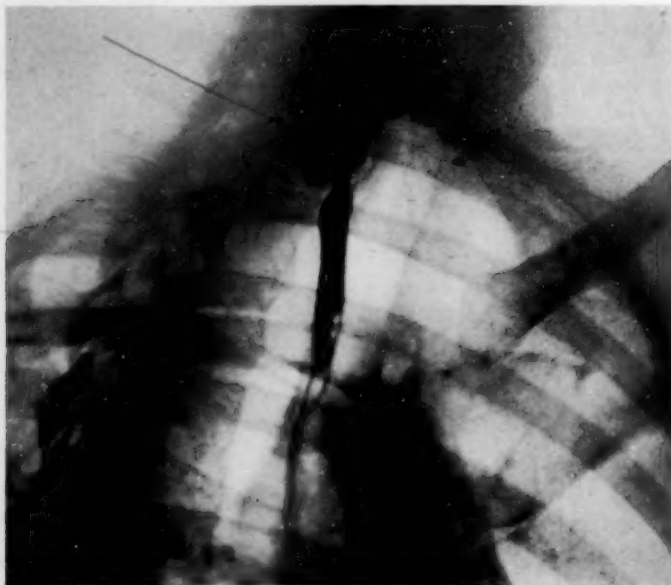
Diverticulum of Œsophagus. X-ray immediately following barium meal.
